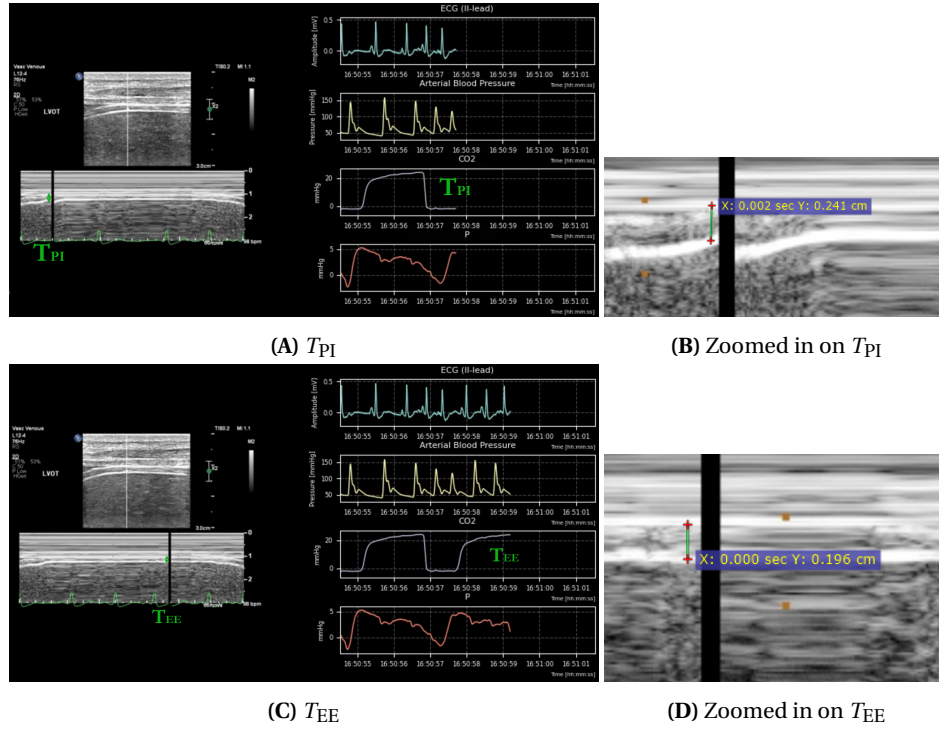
Measurement of diaphragm thickness using M-mode ultrasound synchronized with the CO₂ curve, enabling accurate assessment of the Diaphragm Thickening Fraction. (A) T_{PI} : diaphragm Thickness at Peak Inspiration; (B) zoomed view of T_{PI} ; (C) T_{EE} : diaphragm Thickness at End Expiration; (D) zoomed view of T_{EE} .
